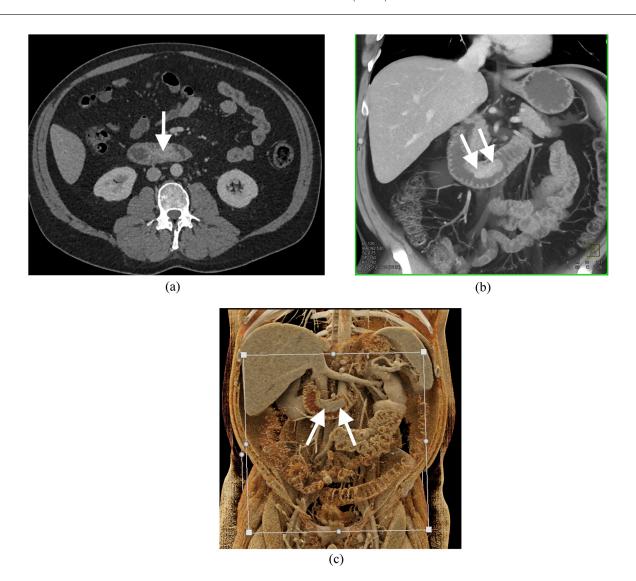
(A–C) 46 y old male presented with severe abdominal pain and diarrhea. CT imaging and endoscopy demonstrated a lobular mass of the duodenum best defined as having a polypoid-type appearance. A Whipple procedure and a subsequent pathology were performed and the patient is currently doing fine on observation. (A) Axial CT demonstrates a mass in the 3rd portion of the duodenum (arrow). (B) Coronal volume rendering of the duodenum defines the enhancing polypoid lesion off the duodenal wall (arrows). (C) 3D imaging with cinematic rendering nicely defines the intraluminal mass and its relationship to normal duodenal folds (arrows).
